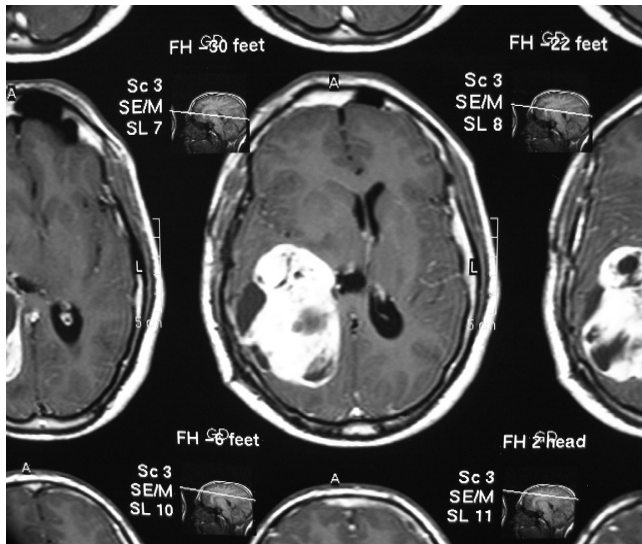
Horizontal section, T1-weighted MRI before his second operation.
